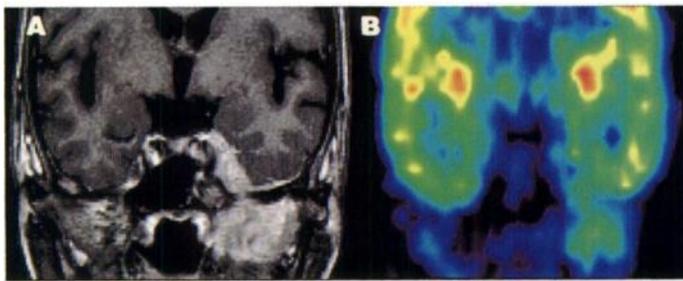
(A) Contrast-enhanced coronal T1-weighted image (gradient-recalled echo, 450/9; flip angle, 90°) shows moderately enhancing tumor in left parasellar region extending into parapharyngeal space via foramen ovale. Tumor also invades cavernous sinus and infraorbital fissure and surrounds left internal carotid artery. (B) FDG PET demonstrates that central part of extracranial tumor is as hypermetabolic as temporal gray matter.
